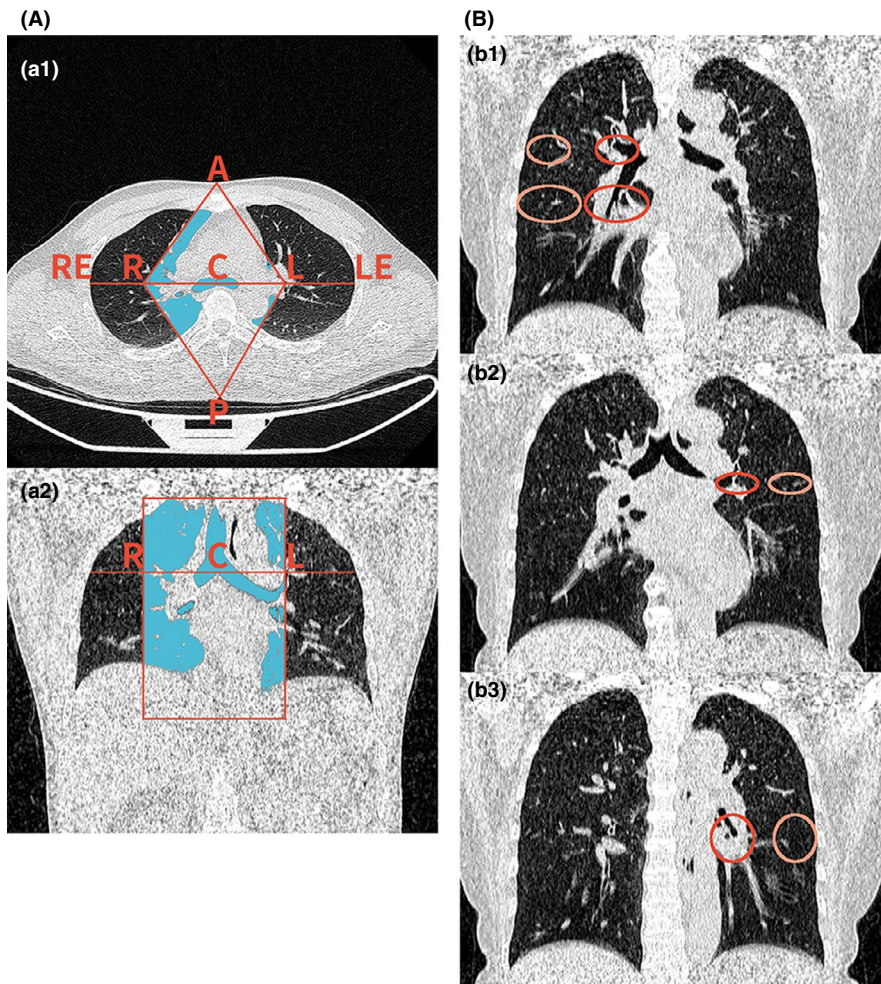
Definition of central area and hilar area in chest CT images. A, the central area was defined as a quadrilateral (ALPR) on the transverse plane on the level of the carina of the trachea(a1), with the four points at A: the anterior median line, P: the posterior median line, L: the midpoint of the carina (C) and the left edge of the lung(LE), and R: the midpoint of the carina (C) and the right edge of the lung (RE). 3D covering all transverse planes was calculated(a2). B, The hilar area was defined as four spheroid regions, of which the centres were located at the end of the right superior lobar bronchus and the end of bronchus intermedius(b1), the end of the left superior lobar bronchus(b2) and the end of left inferior lobar bronchus(b3). The radius of each spheroid region was determined by the linear distance between the centre and the next generation of bronchial bifurcation (red circles). Peripheral areas were determined by moving the spheroid regions laterally adjacent to pleura (orange circles)
